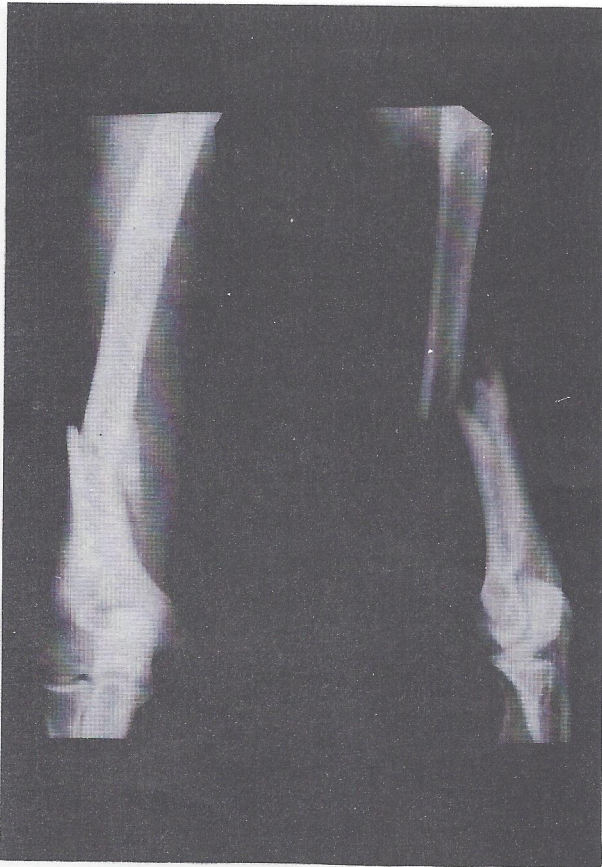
Anteroposterior and lateral radiographs of the humerus showing distraction of the fragments.
